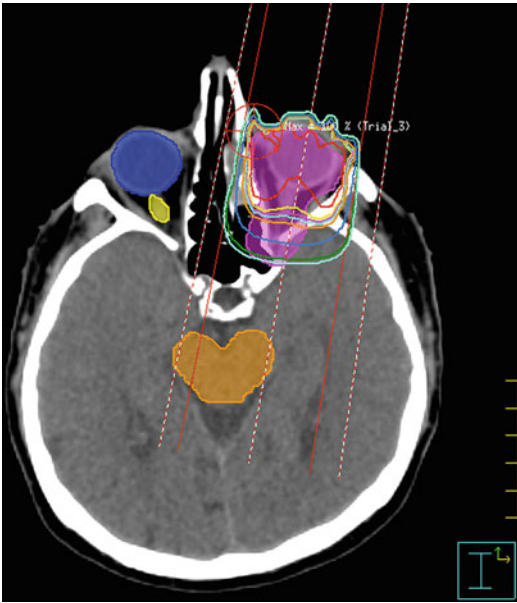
Axial CT with *en face* photon beam demonstrating coverage of the planning target volume (PTV) covered by the 95 % isodose line (*aqua*)
